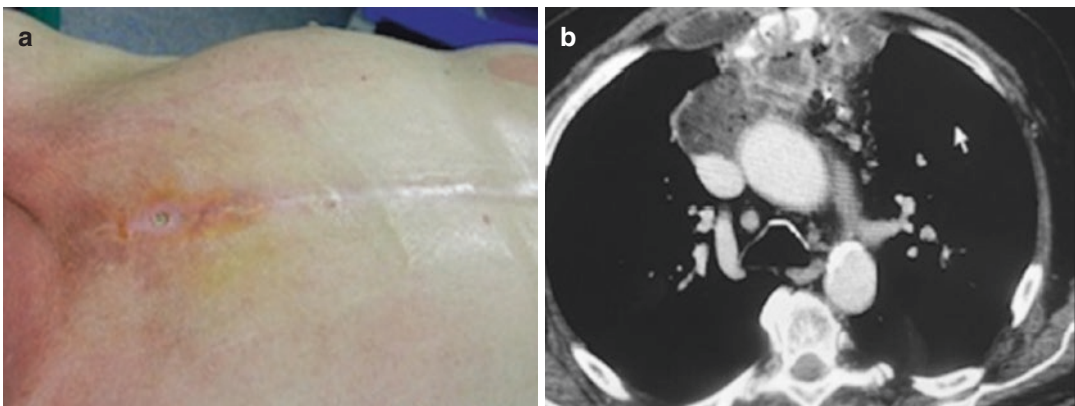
Another case of SWD entailing minimal dehiscence of the skin wound and advanced mediastinitis with sternal dehiscence revealed by the CT scan
